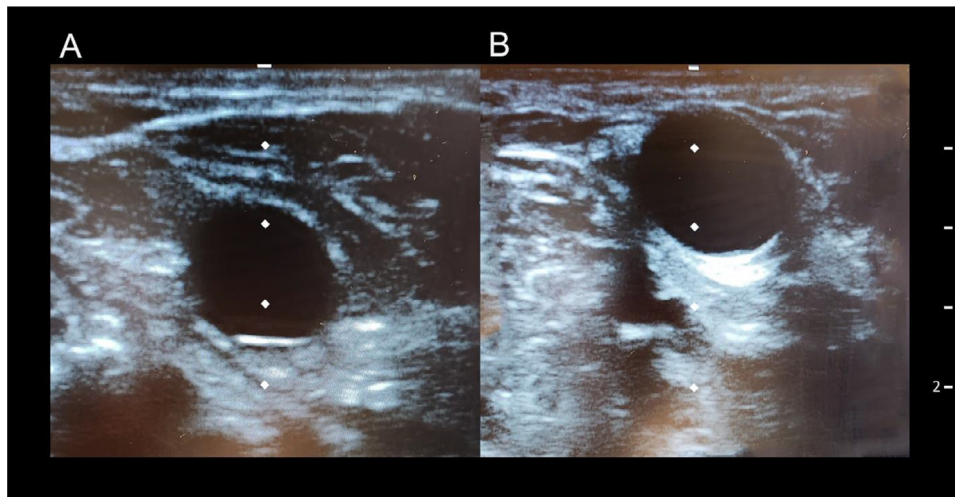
Ultrasound examination of the arteriovenous fistula before (A) and after (B) liposuction.
